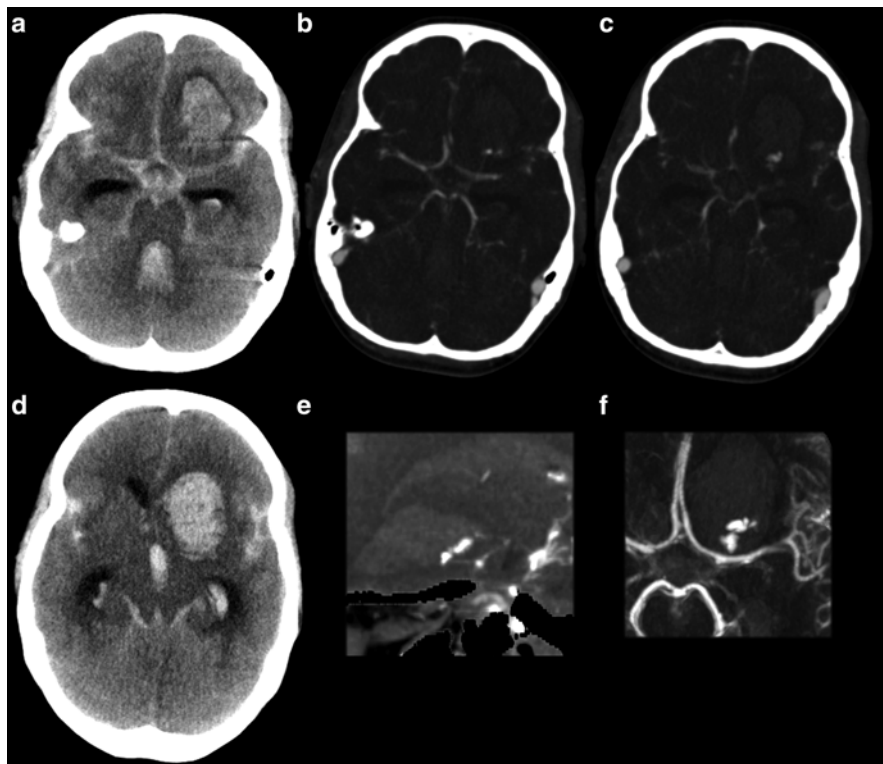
Thirty-five y/o female presented postpartum with hypertension, headache, and seizures. NECT showed a large left frontal hematoma and severe subarachnoid hemorrhage, including intraventricular hemorrhage and hydrocephalus. CTA showed a vascular malformation at the left frontal lobe, suggestive of an AVM. NECT at presentation (a and d). Source images of the CTA (b and c). Lateral and transverse MIP reconstruction (e and f)
